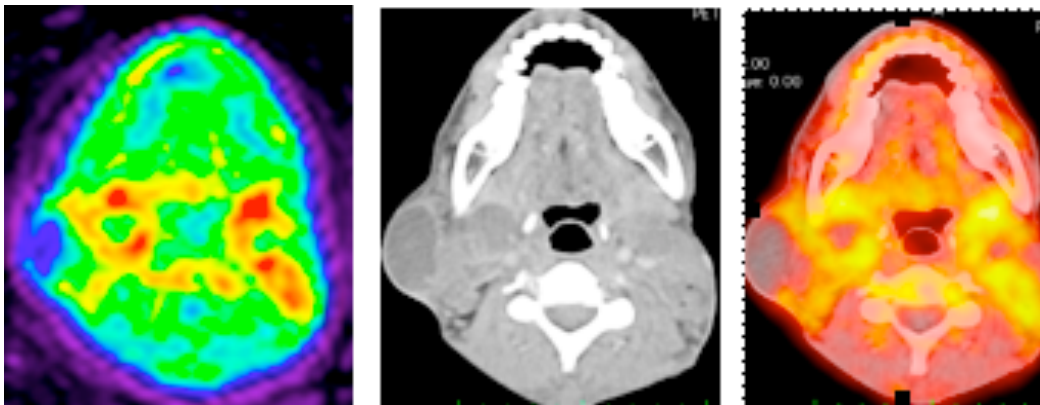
40 yr old man with TB and HIV-co-infection demonstrating enlarged lymph nodes with necrotic centers and peripheral rim tracer accumulation, similar to what has been demonstrated with ^{18}F -FDG PET/CT. 232MBq (6.3 mCi) of ^{68}Ga -citrate was injected IV, uptake time 60 min, IV contrast given.
